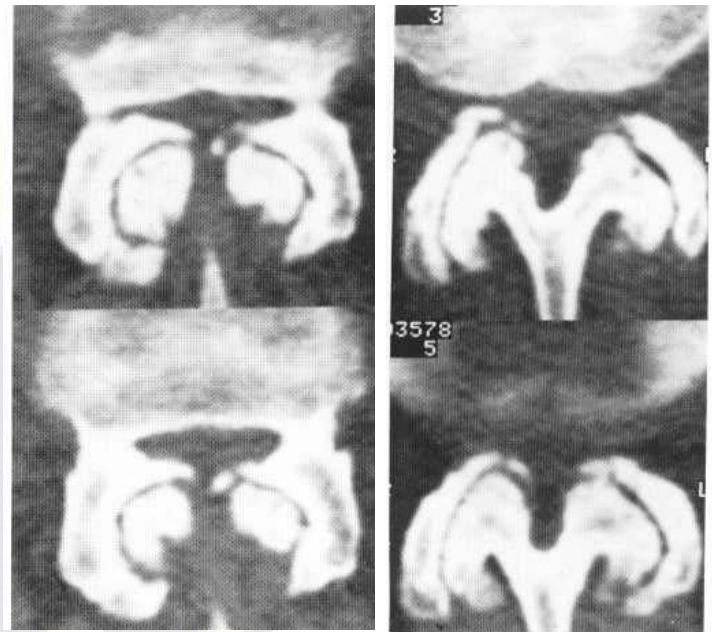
Canal stenosis. CT sections through lumbar spinal canal. Note the short pedicles (bottom right image) and medially placed apophyseal joints. The combination causes marked reduction of the sagittal diameter of the lateral parts of the spinal canal, which is further compromised by osteoarthritic changes in the apophyseal joints.
